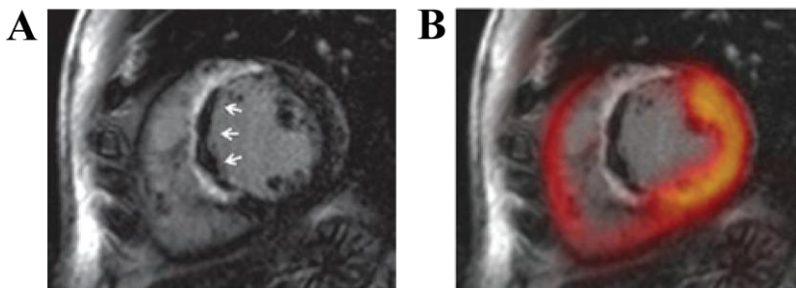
Short-axis images obtained by hybrid PET-MRI in a patient with myocardial infarction of the septal and anteroseptal wall.
